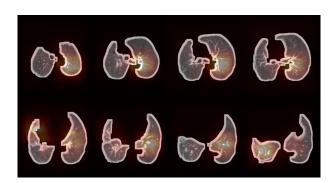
The class activation mappings generated on Covid-Net3D on a chest CT scan of the Clean-CC-CCII dataset. Regions colored in red and brighter has more impact on model's decision to the class of COVID-19 while blue and darker region has less.
